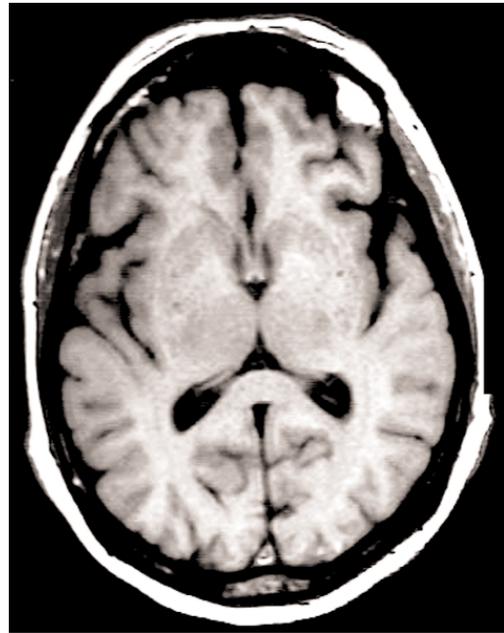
An inverted MRI scan of the brain showing the dorsomedial nucleus and the interthalamic adhesion where midline nuclei are located
